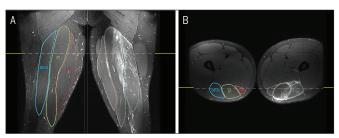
Magnetic resonance imaging 6 days after injury. (A) Coronal and (B) axial T2-weighted images of the thighs demonstrating increased T2 signal (increased brightness) in the left BFLH, surrounding a thickened proximal musculotendinous junction and tracking along the muscle's fascicles in a feathery pattern. Axial images reveal ST involvement. The yellow lines represent the locations of coronal and axial slices. Abbreviations: BFLH, biceps femoris long head; SM, semimembranosus; ST, semitendinosus.
